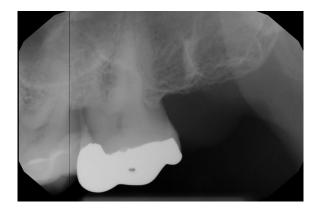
Periapical radiograph showing a normal trabecular pattern. A section of tooth root-like opacity is seen in the alveolus.
